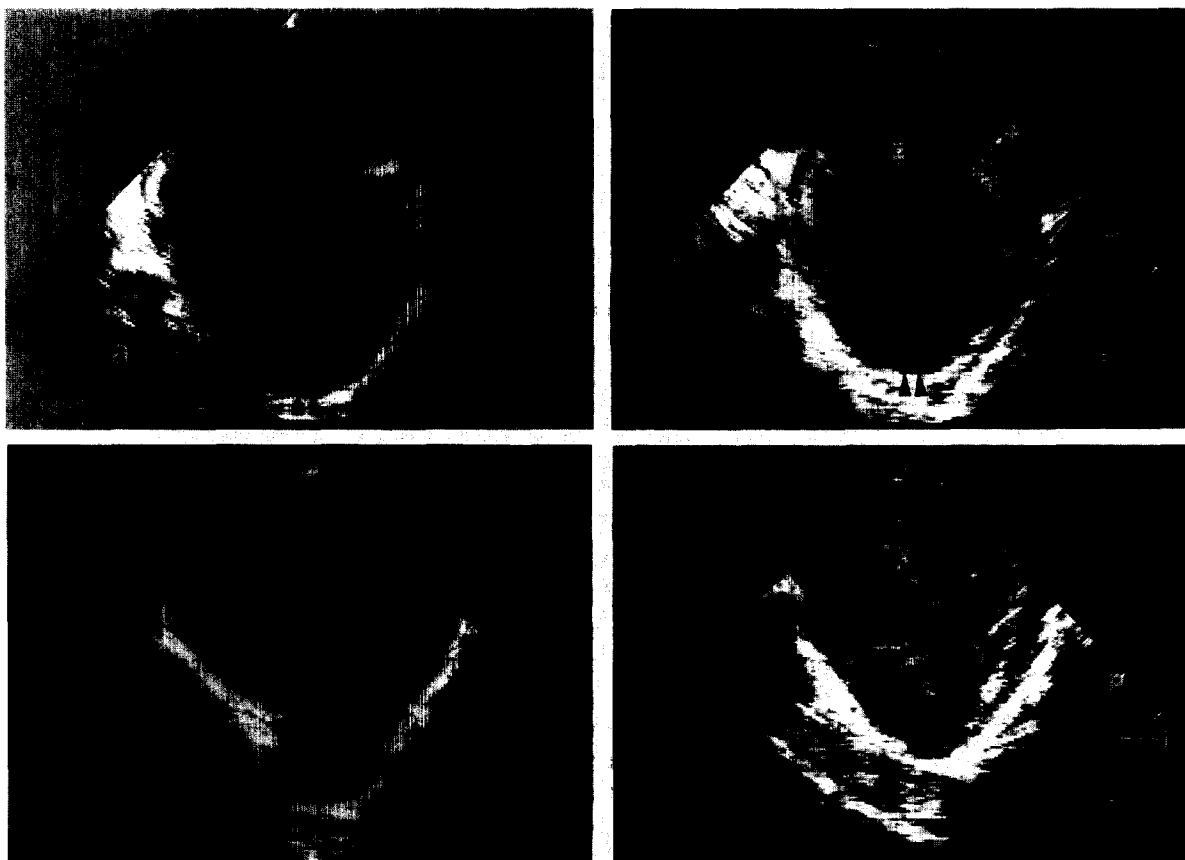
Transesophageal echocardiographic images before and immediately after the hemi-Fontan procedure in a patient with a single left ventricle (SLV). Transverse four-chamber view before (a) and after (b) operation and transverse short-axis view before (c) and after (d) operation. Note the decrease in ventricular cavity dimension and increase in wall thickness after operation. Ventricular septal defect diameter decreased by 27%. Arrowheads indicate posterior wall thickness (a and b) and borders of ventricular septal defect (c and d). a = anterior; Ao = aorta; AVV = atrioventricular valves; l = left; p = posterior; r = right.
